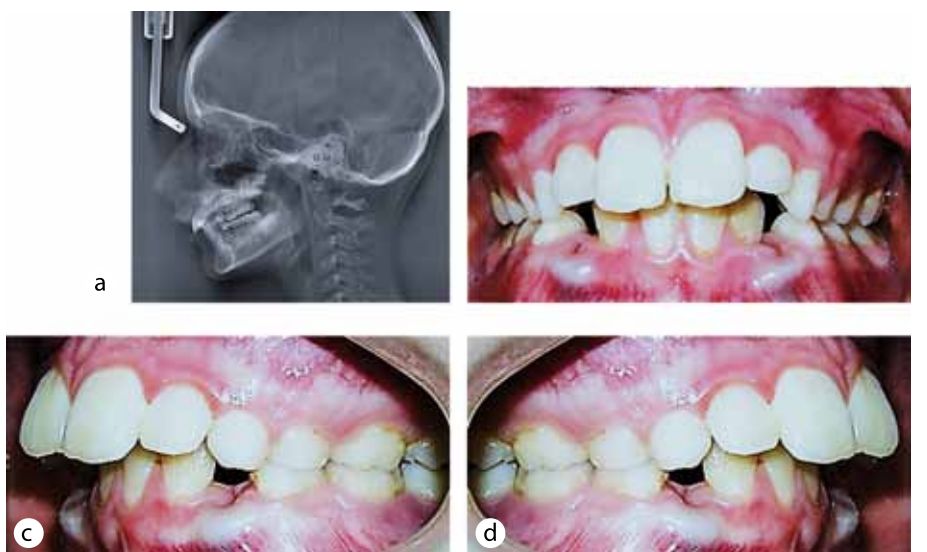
X-ray and photographic features of dental system, patient A., 11 y.o., with moderate CTD. Head telorentgenogram, lateral projection (a), pathological occlusion (b — direct projection, c — left-side lateral projection, d — right-side lateral projection)
